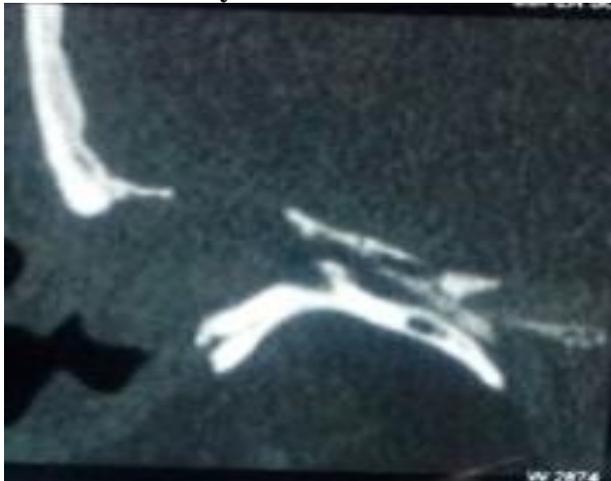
CT showing a defect of 10mm in tegmen of right temporal bone.
